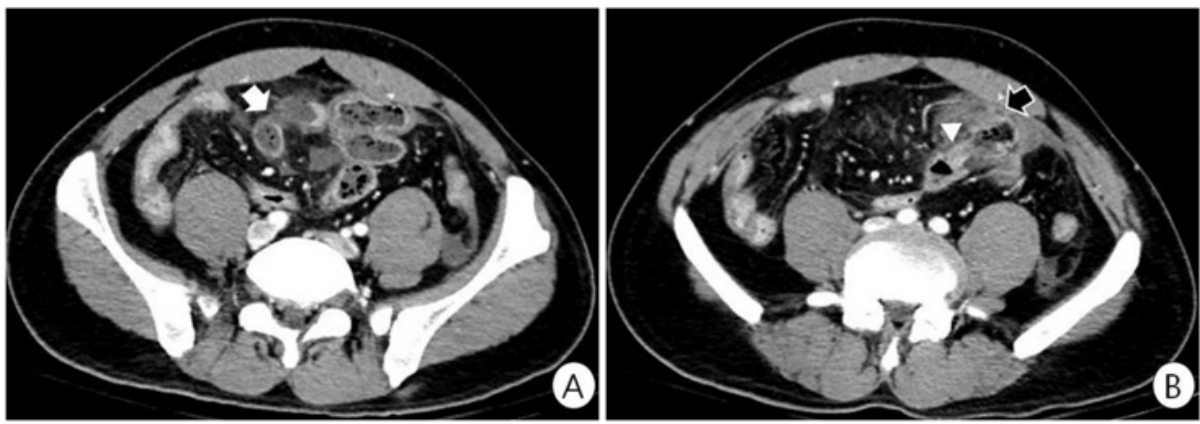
CT scan (axial image at the level of sacral promontory) shows (A) dilated left sided appendix (arrow) with wall enhancement, fat stranding and peritoneal thickening, (B) cecum (arrow) and ileocecal valve (arrowhead).
